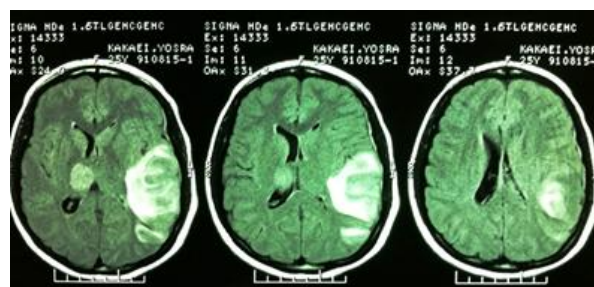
Axial fluid attenuated inversion recovery (FLAIR) images demonstrate two areas of infarction; in left temporo-parietal region and right thalamus. Associated brain CT scan (not represented here) revealed non-homogenous hemorrhage in the temporo-parietal infarcted region.
